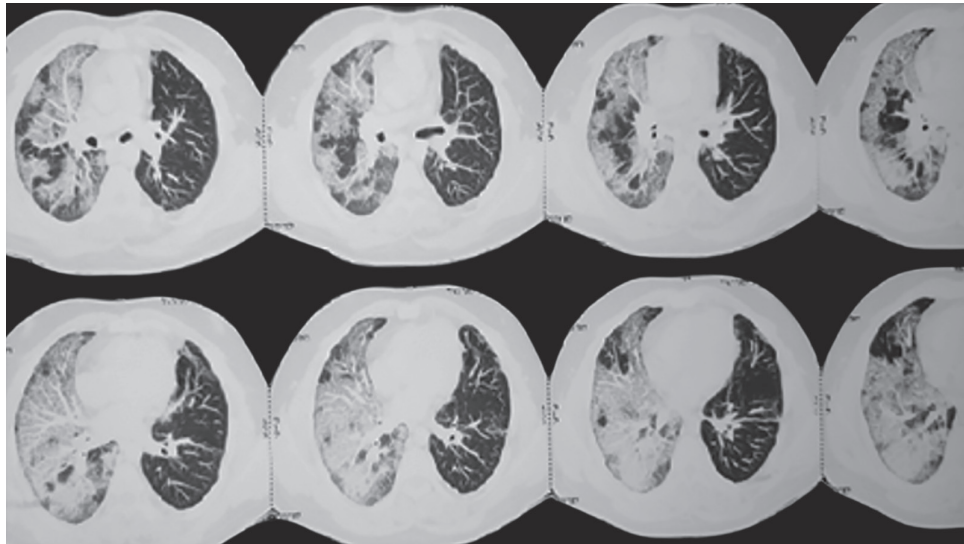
High-resolution computed tomography thorax showed right-sided, ground-glassing with interstitial septal thickening (left lung is almost normal)
